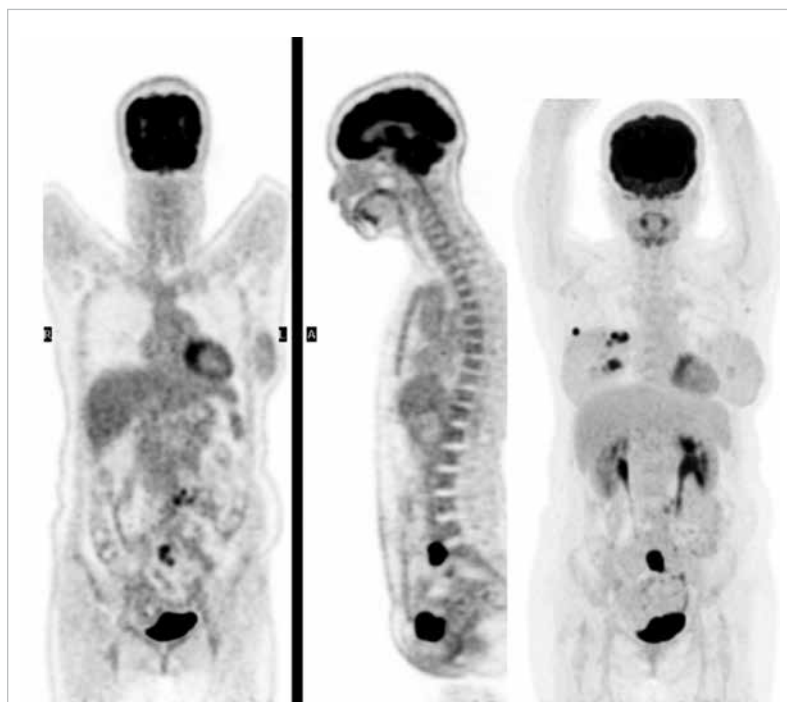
Positron emission tomography-computed tomography showing multiple hypermetabolic soft tissue masses at the upper outer, upper inner and lower inner quadrants of the right breast measuring up to 16 mm, with maximum standardised uptake value 19.0; and multiple hypermetabolic abdominal lymphadenopathies
